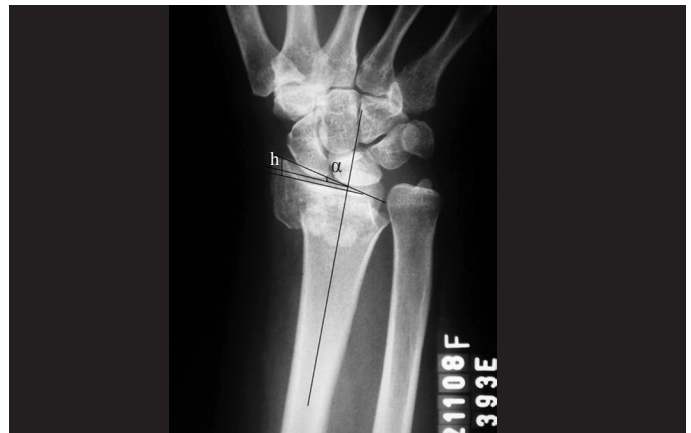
Preoperative radiograph on wrist in posteroanterior (PA) view, showing an extra-articular fracture of the distal radius with metaphyseal comminution and diminished radial inclination. The radial inclination (α) and radial height (h) are demonstrated on the radiograph.
